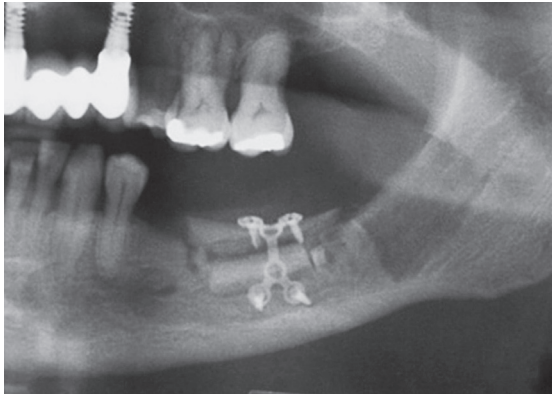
Immediate panoramic radiograph showing the reconstruction that was performed.
